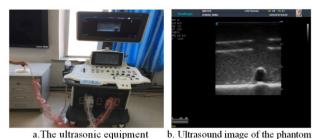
the ultrasound equipment and the result
